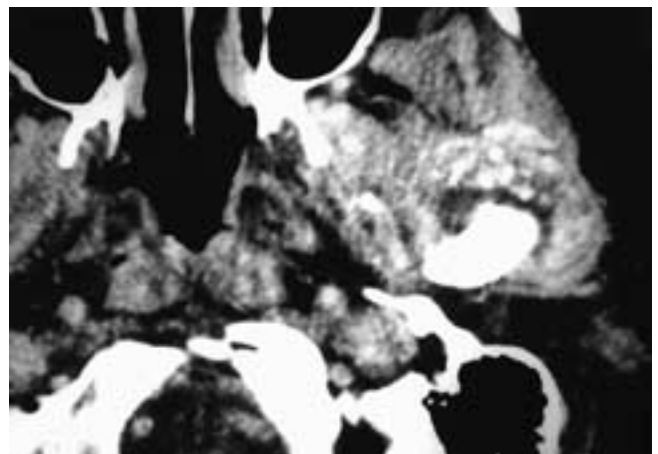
Axial CT scan shows a partially calcified mass involving the left TMJ. There is also fluid in the joint. This mass was clinically suspected of being a parotid tumor. This patient had a synovial chondromatosis.
